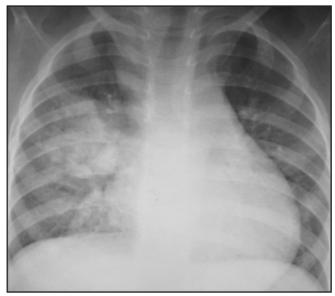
Chest radiograph taken at three years of age showing similar opacities.
